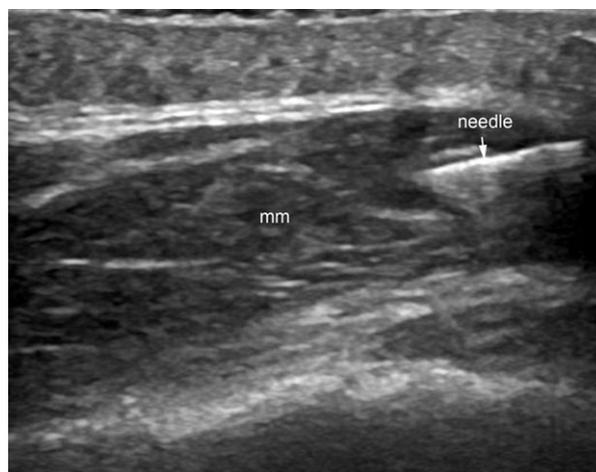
Ultrasound-guided Botulinum type A injection in the masseter muscle (gray scale, transverse view) shows the tip of the needle (arrow) within the muscle (mm).
